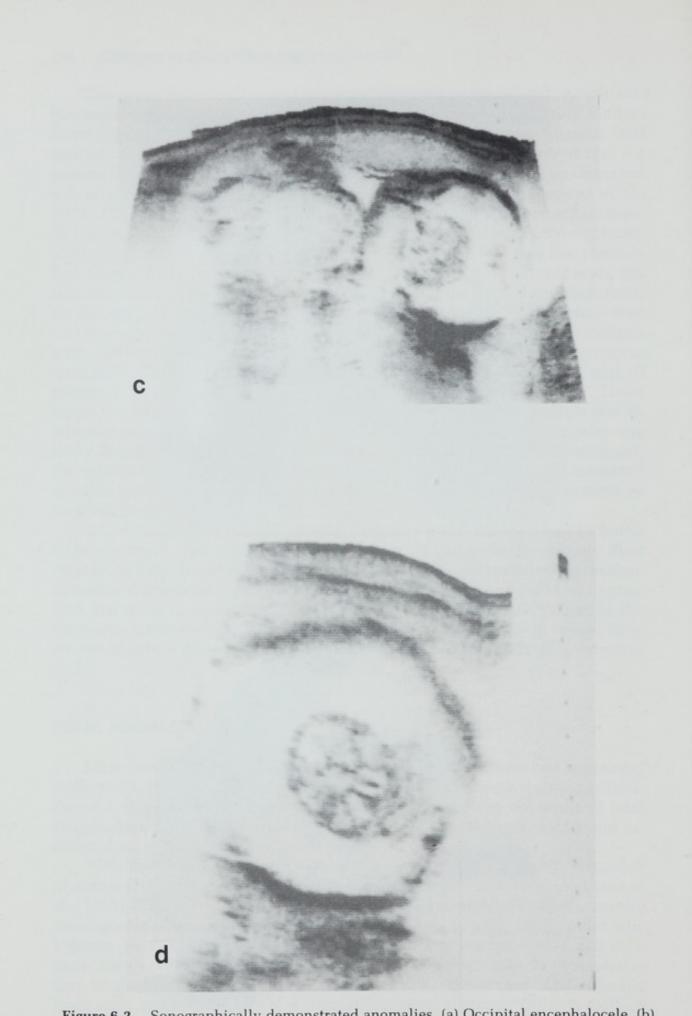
Sonographically demonstrated anomalies. (a) Occipital encephalocele. (b) Cystic hygroma. (c,d) Hydranencephaly.
